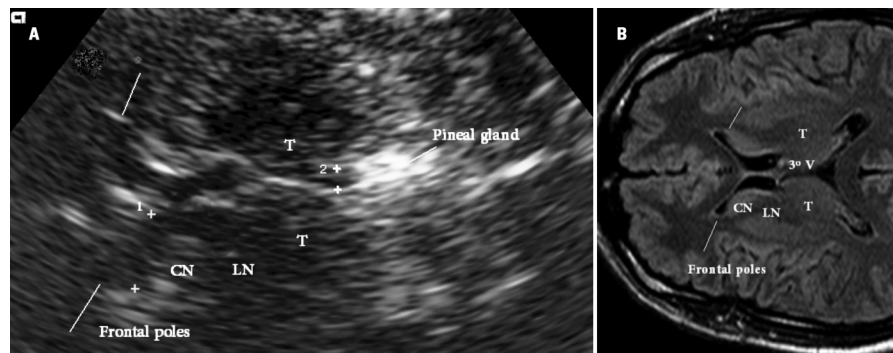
Ventricular and basal ganglia plane images on Transcranial Sonography (TCS) and Magnetic Resonance (RM). [A] TCS axial plane 10°-20° above the orbitomeatal line (zoomed image) (1) transverse frontal horn diameter, (2) transverse 3rd ventricle diameter; [B] MR image (FLAIR FAST), similar axial plane (not the same person) (T) thalamus, (LN) lenticular nucleus, (CN) caudate nucleus.
